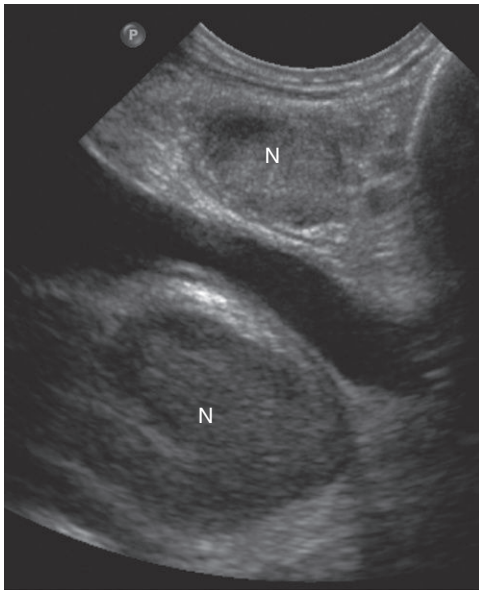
Gray scale ultrasound in the sagittal plane shows several enlarged malignant nodes (N) in the neck and upper mediastinum creating an obstruction in the vein.
